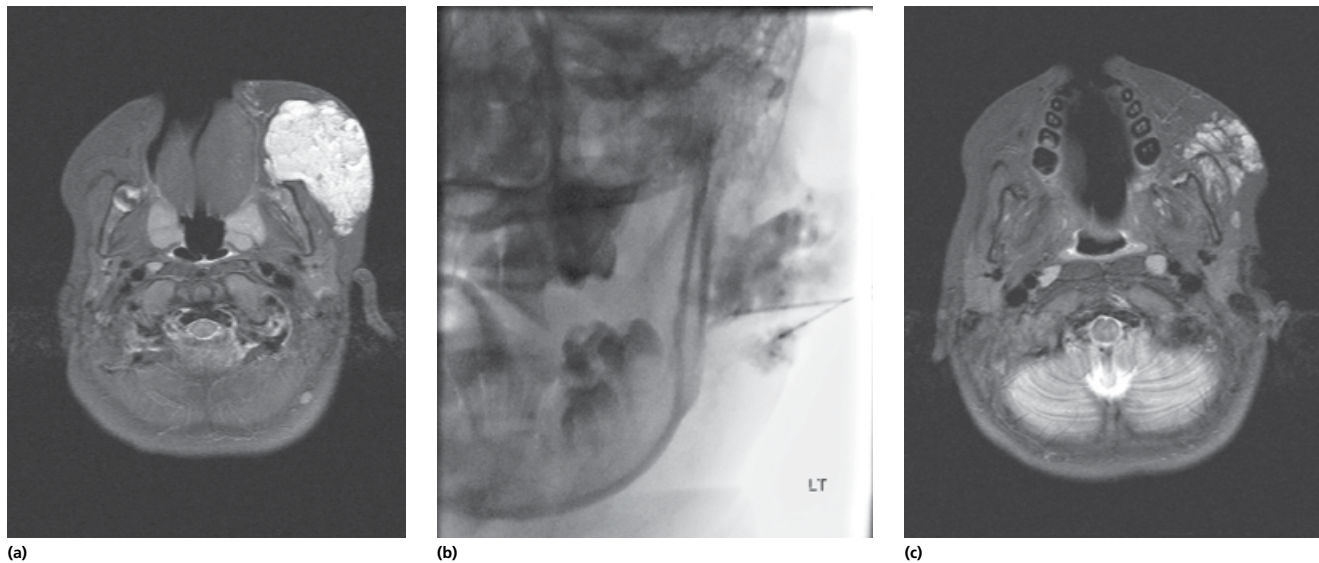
(a) T2-weighted axial MRI image of a venous malformation of the left cheek in a child. The malformation is visualized as a lobulated, well-defined mass within the subcutaneous tissue. (b) Intraoperative fluoroscopic image of sclerotherapy of the lesion. A two-needle technique was used to instill opacified sclerosant into the malformation. (c) T2-weighted axial MRI image of the same venous malformation following four sclerotherapy treatments. The malformation was considerably reduced in size and the distortion of the adjacent soft tissues of the cheek was lessened.
